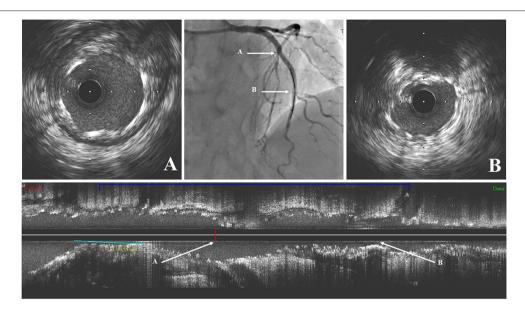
The intravascular ultrasound findings after stenting. (A) Cross-sectional intravascular image of LAD stent just proximal to the septal branch branching point; (B) Cross-sectional intravascular image of LAD stent just proximal to the 2nd diagonal branch branching point. LAD, left anterior descending coronary artery.
